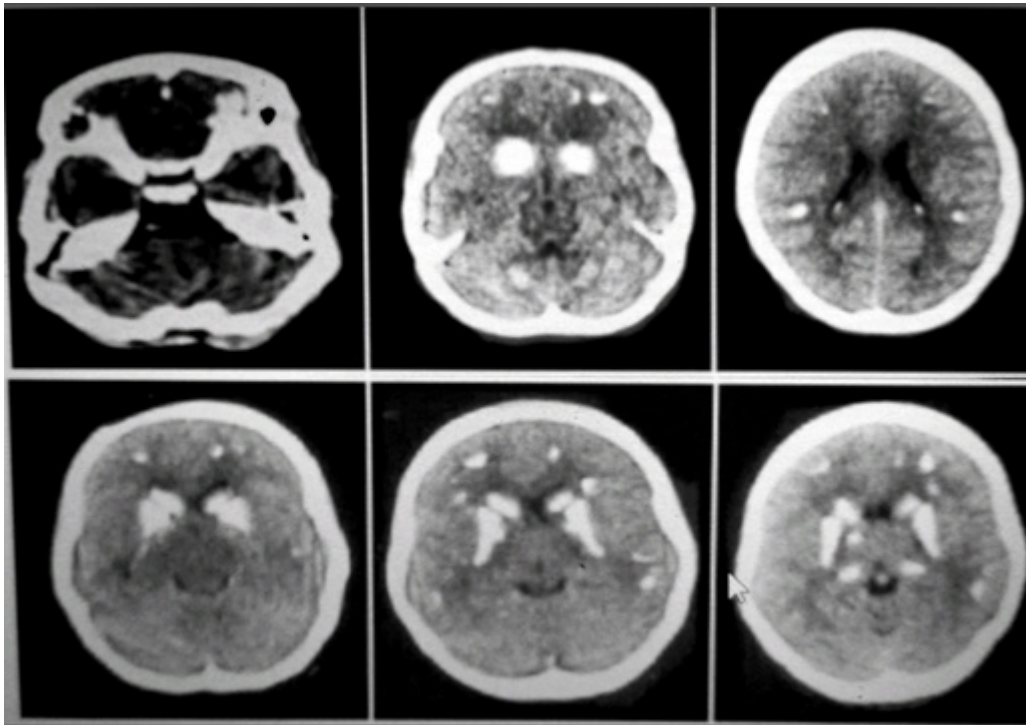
A computed tomography scan of the brain.
